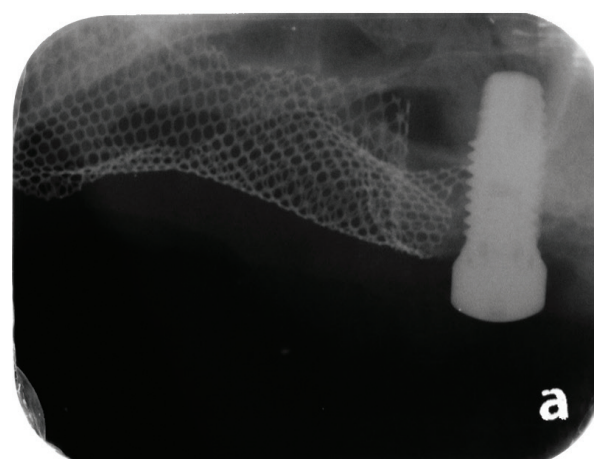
Periapical film of the implant with healing abutment.
